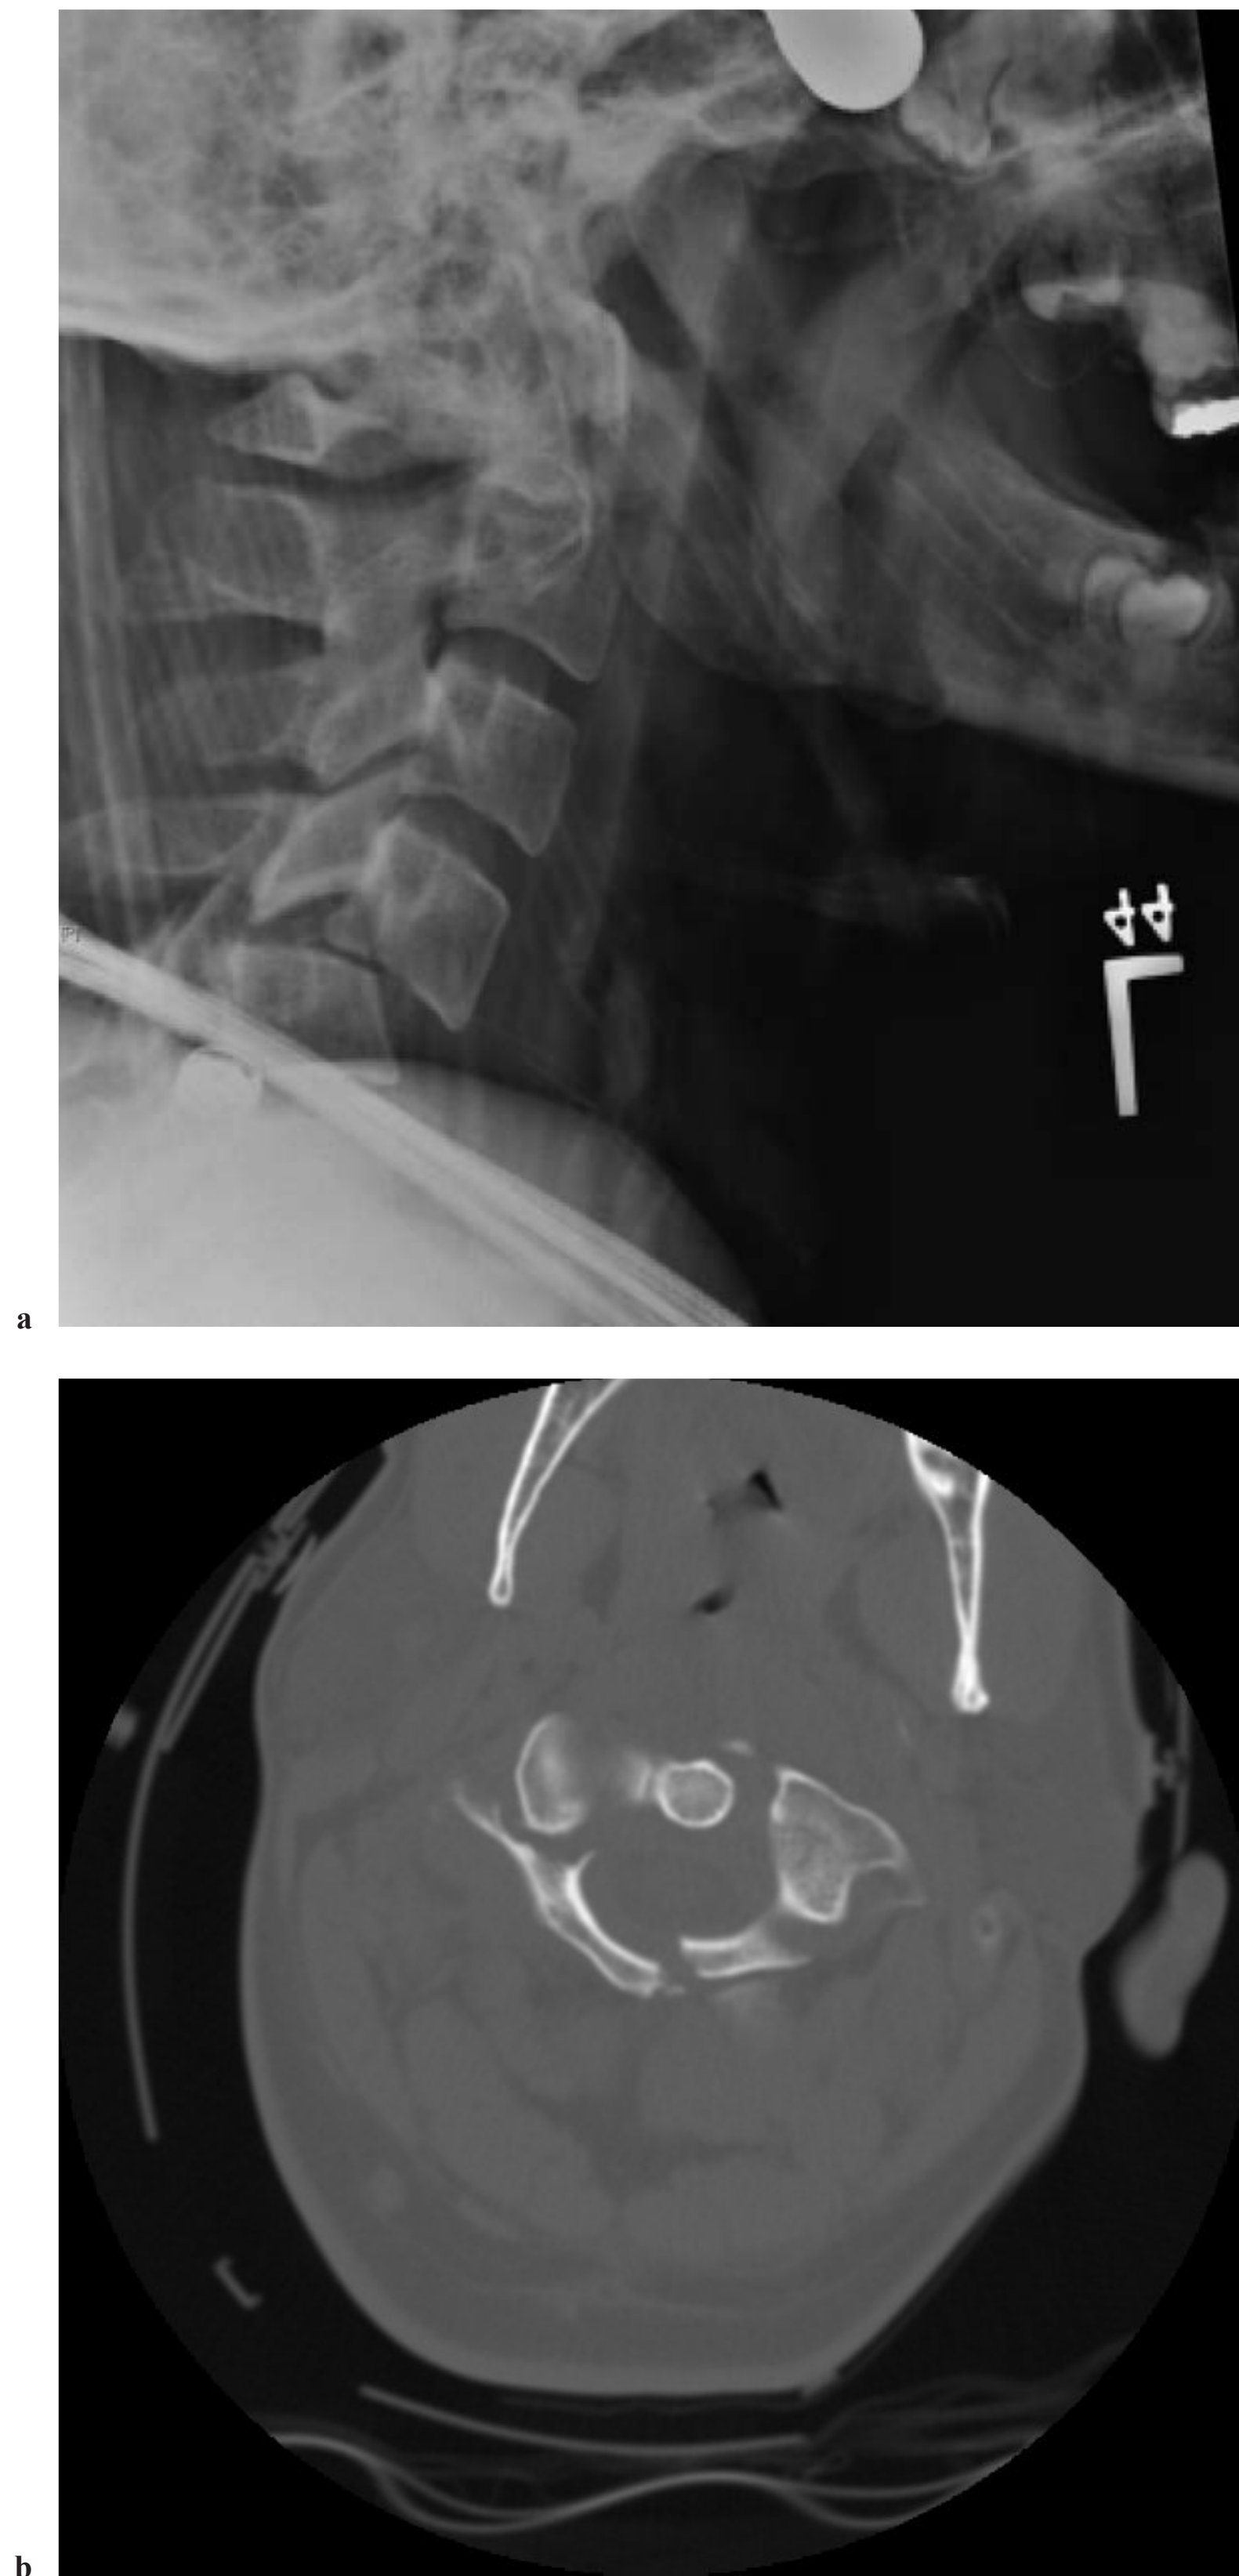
Lateral radiograph in patient with high-grade spondylolysis at C4-5 due to bilateral facet dislocation after traction tongs placement and prior to weight application.
